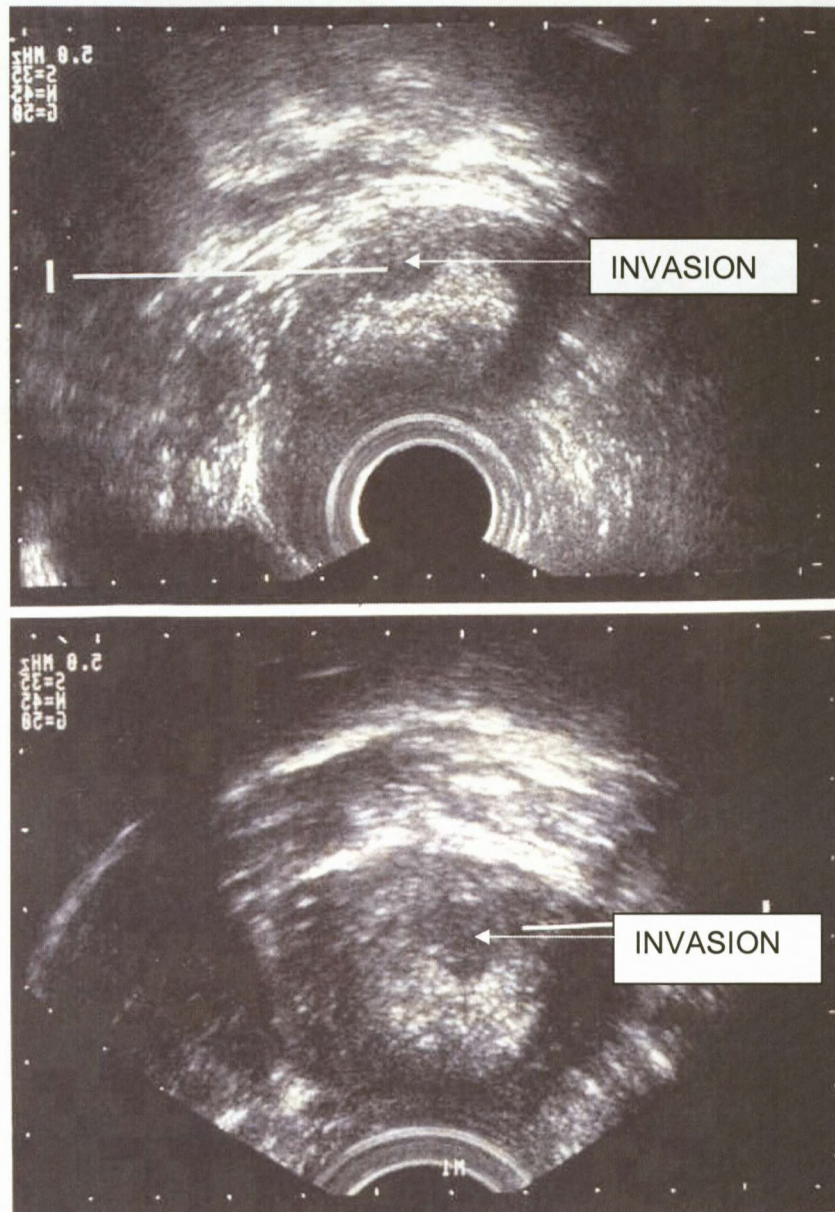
TRANSVAGINAL ULTRASOUND SHOWING ENDOMETRIAL CARCINOMA (Adapted from: Bernaschek *et al.* 1990).
